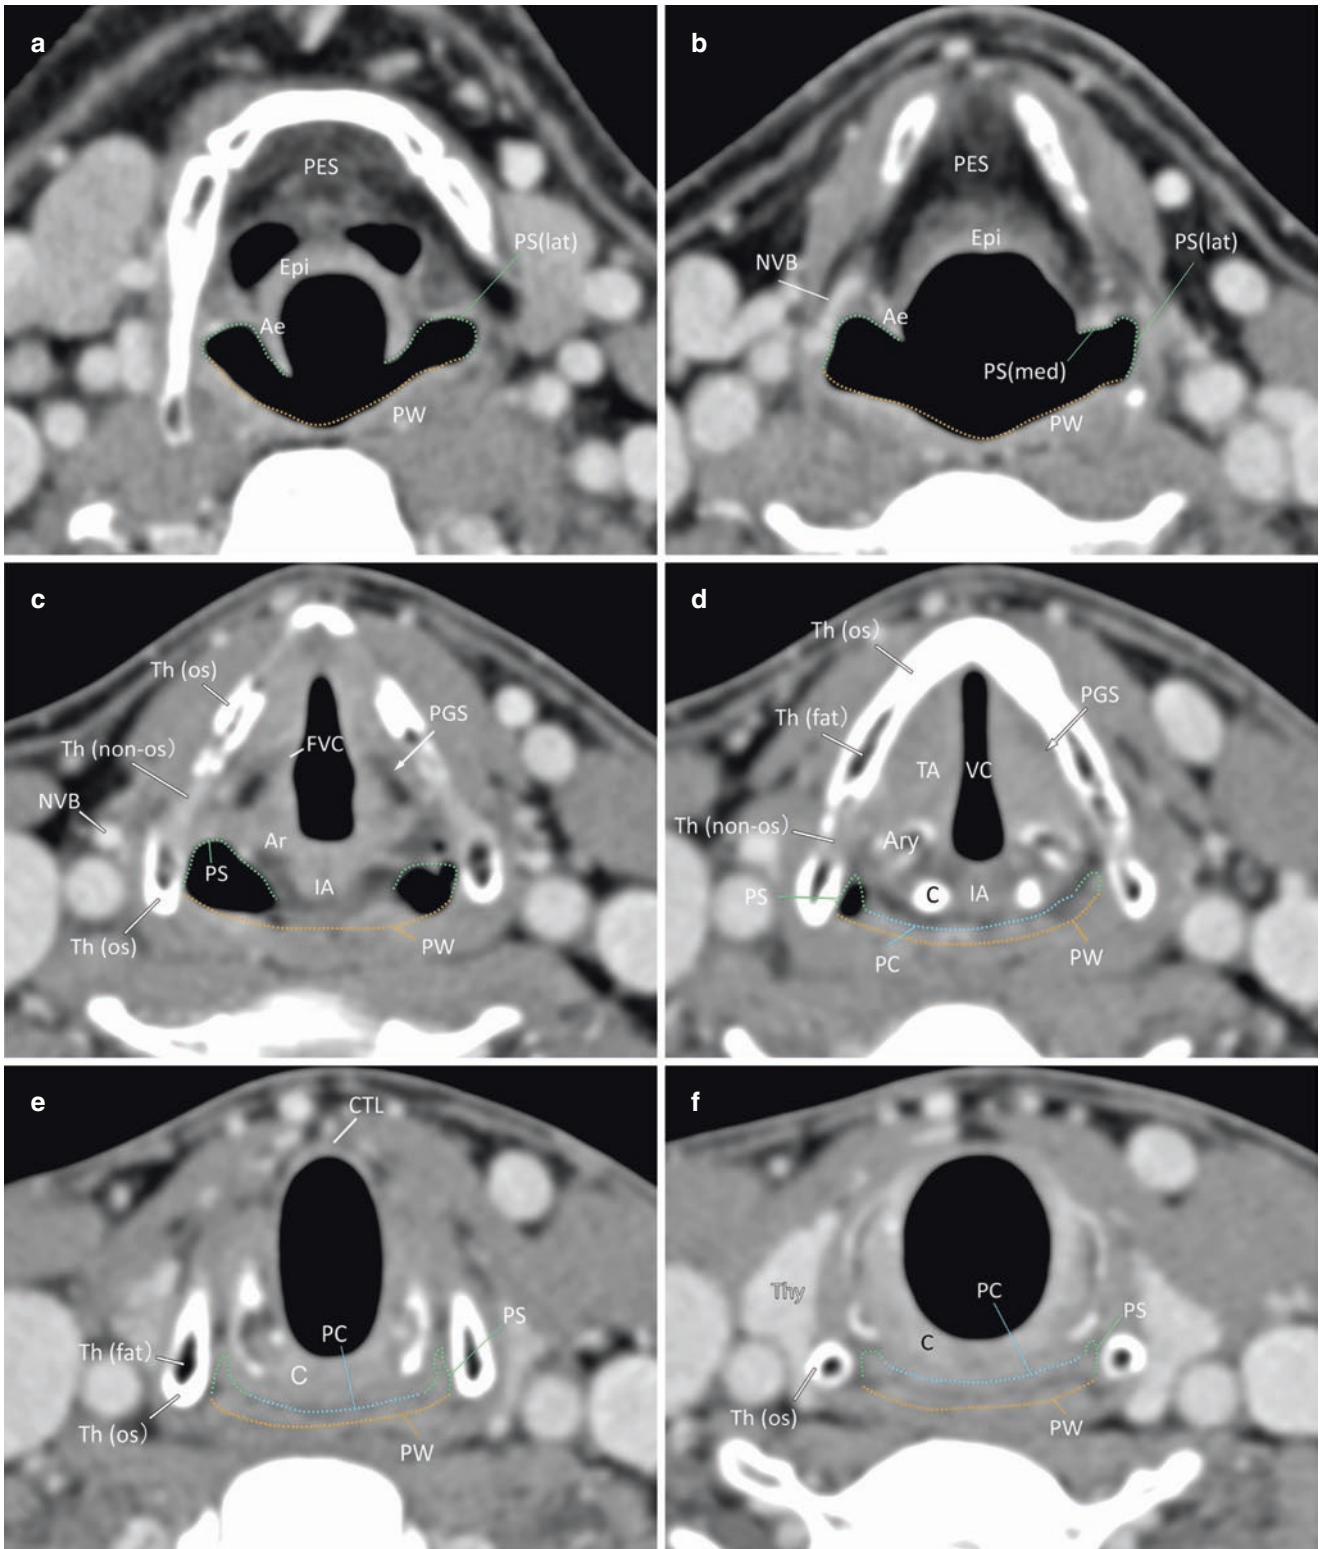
CT anatomy of larynx and hypopharynx (a-f). The hypopharynx is divided into the pyriform sinuses (green), posterior hypopharyngeal walls (orange), and postcricoid region (blue). *Th (os)* ossified thyroid cartilage, *Th (non-os)* non-ossified thyroid cartilage, *Th (fat)* fat
